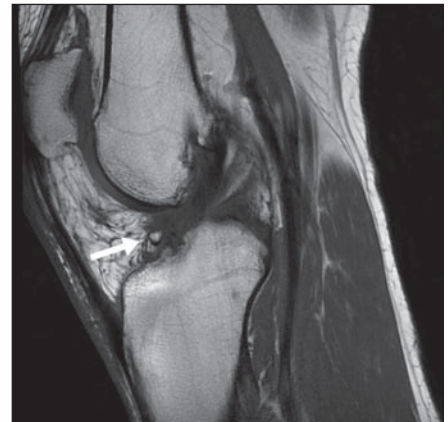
Focal arthrofibrosis in 26-year-old man who presented for follow-up imaging after anterior cruciate ligament reconstruction. Sagittal proton density-weighted MR image shows focal area of decreased signal intensity (*arrow*) just anterior to distal end of graft between femur and tibia.
